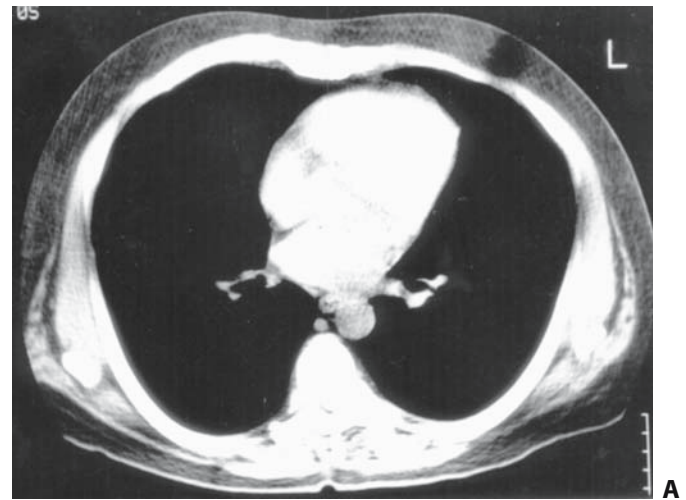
(A) Computed tomography of the pericardium. Normal pericardium was not imaged. (B) Fungal constrictive pericarditis. (C) Mesothelioma.
